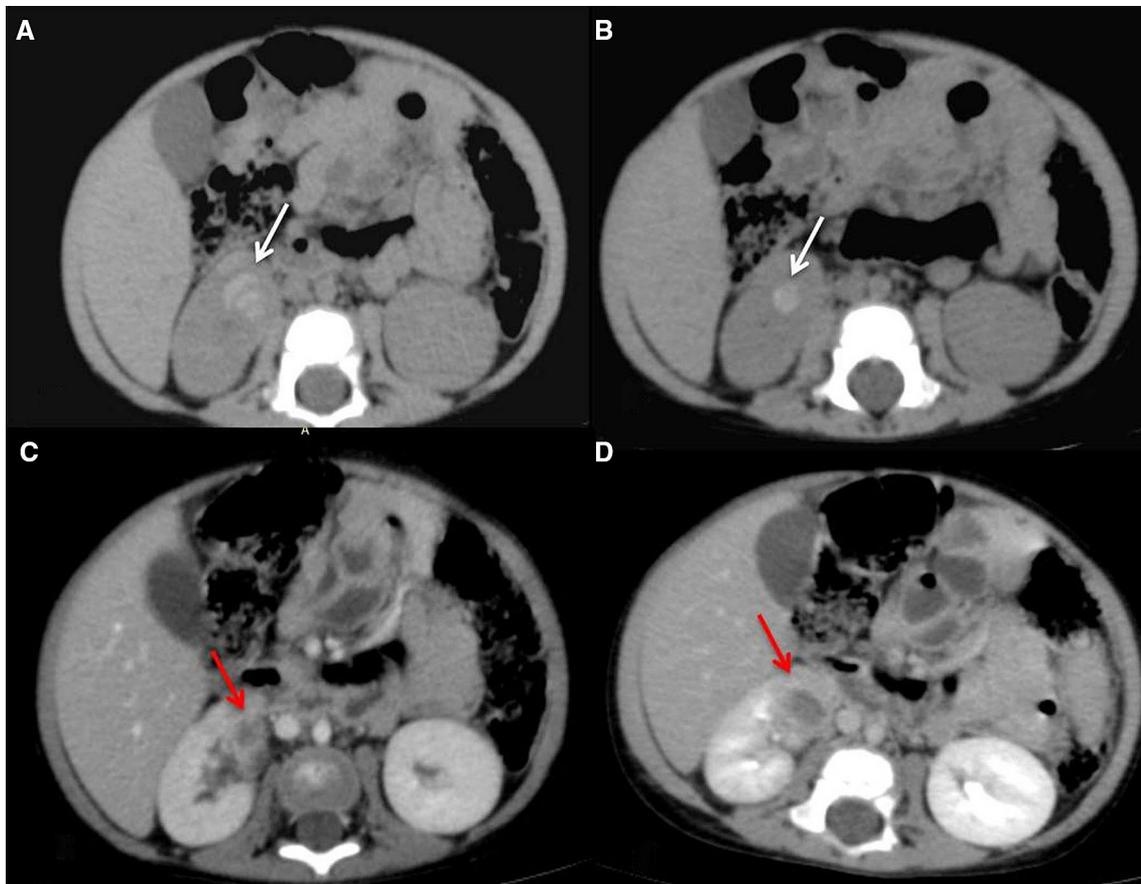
A–D CT study in a male infant of 8 months with a palpable mass in the right lumbar region. NCCT study A, B shows a mass lesion in the lower pole of right kidney with few hyperdense foci (white arrows) due to hemorrhage. The contrast CT C, D shows a heterogeneously hypodense tumor
